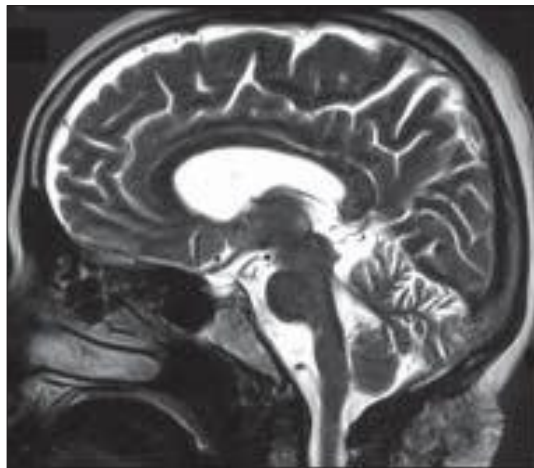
T2-weighted MRI showing evacuation of the arachnoid cyst
